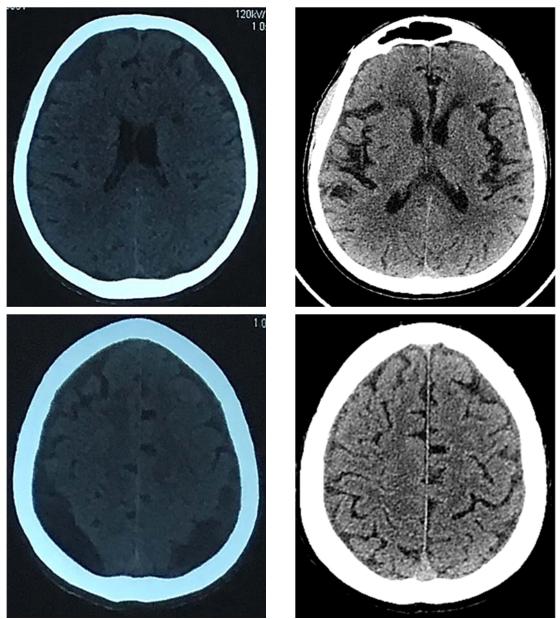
Control CT scan before retransfer showing bilateral chronic subdural hematoma (homogenously hypodense) with a resolution tendency
